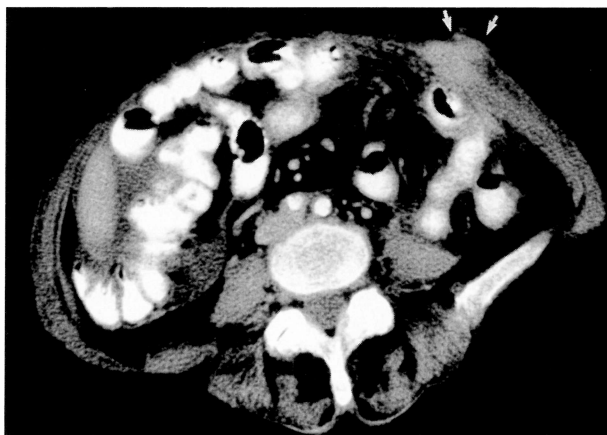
Case No. 1: Abdomino-pelvic CT scan performed two months after laparoscopy. A heterogeneous nodular lesion was visualized inside the left oblique muscle (arrows).
